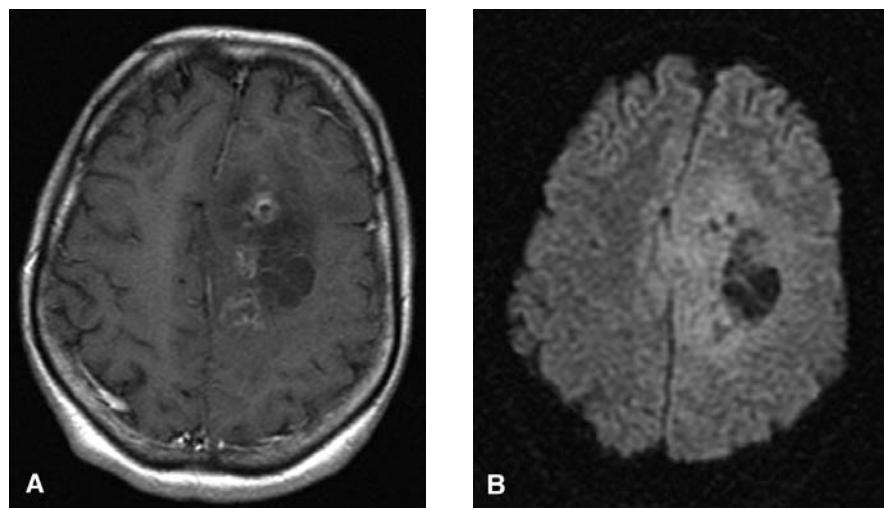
A 38-year-old woman with a glioblastoma multiforme. (A) Axial T1-weighted image demonstrates enhancing tumor and areas of necrosis. (B) Axial DWI shows focal areas of decreased diffusion corresponding to areas of high cellularity (contrast enhancement on the T1-weighted images) as well as increased diffusion that correspond to areas of tumor necrosis (low signal on the T1-weighted images). *Source:* Reprinted from Ref. 66 with permission from Elsevier.
